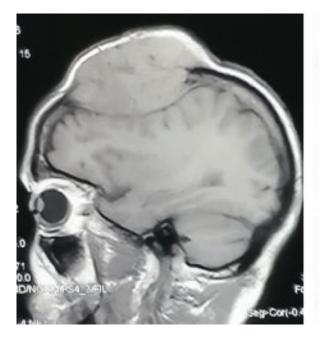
Sagittal view & Coronal view of contrast MRI
